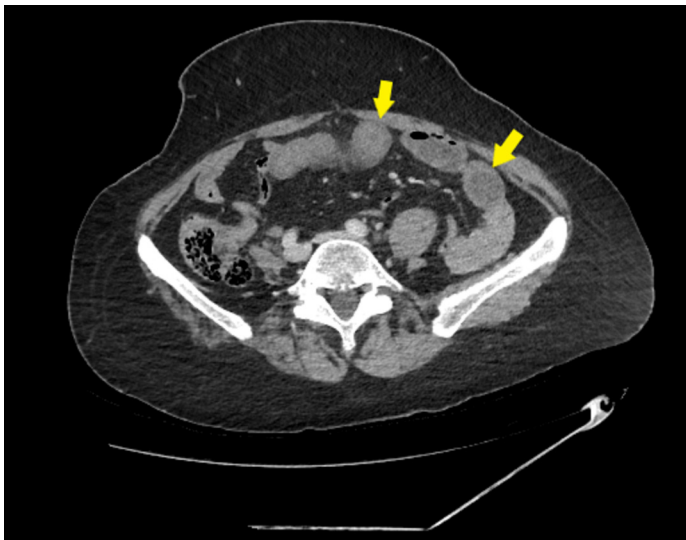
On computed tomography scan, yellow arrows indicate dilated intestinal segments
